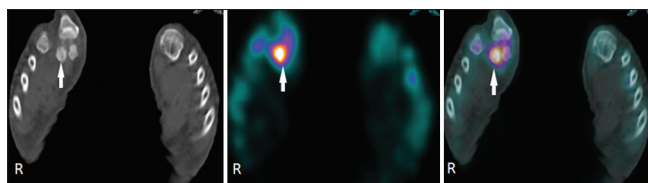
Single photon emission tomography-computed tomography (SPECT-CT) images of feet. CT images (a) do not show any abnormality of right lateral sesamoid (arrow). SPECT (b) and SPECT-CT (c) images show focal uptake of radiotracer in right lateral sesamoid (arrow) [R: Right]
